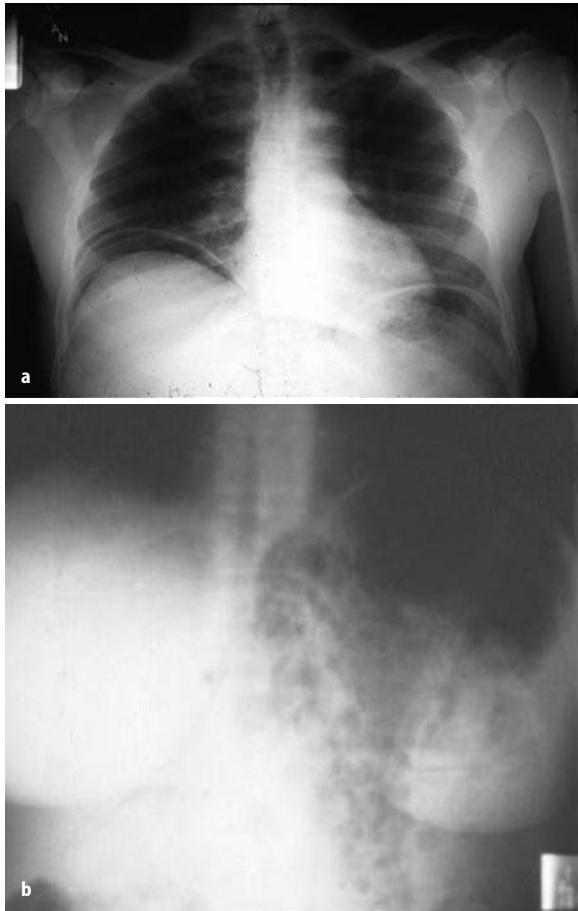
a Plain radiographs demonstrating free air on an upright film of the abdomen; and b: taken with the patient's right side down showing blebs of gas in the wall of the colon at the splenic flexure (pneumatosis caused by vascular compromise). The center of radius of the gas bubbles does not lie in the lumen of the bowel, indicating that the colon is most likely perforated
